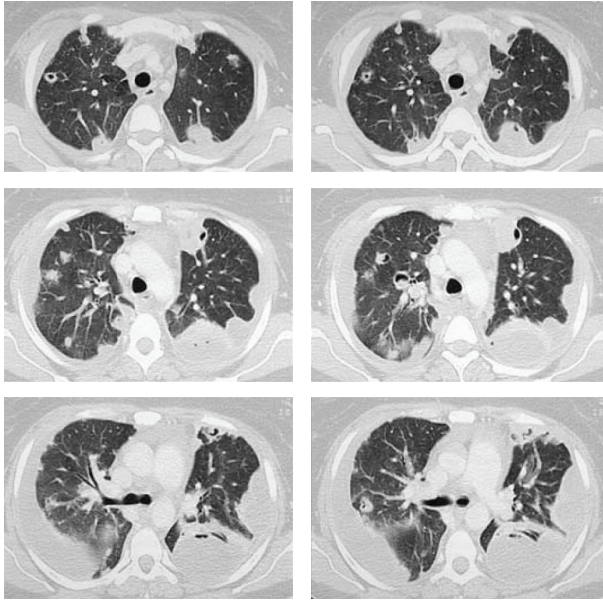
CT scan revealed nodular opacities and diffuse bilateral infiltrates.
